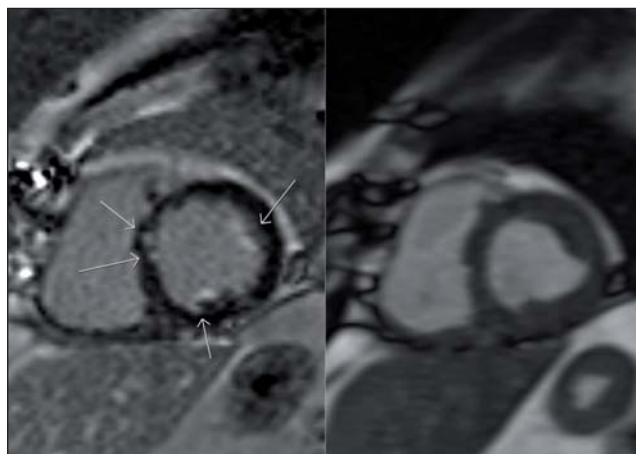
Cardiac magnetic resonance imaging (CMR) showing left ventricular wall thickness and diffuse subendocardial delayed enhancement in a patchy pattern.
